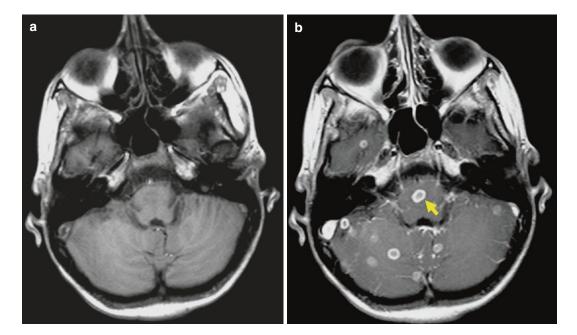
Axial cranial T1-weighted MRI image before (a) and after (b) gadolinium administration. There is a bulbar tuberculoma (*arrow*) with multiple others
